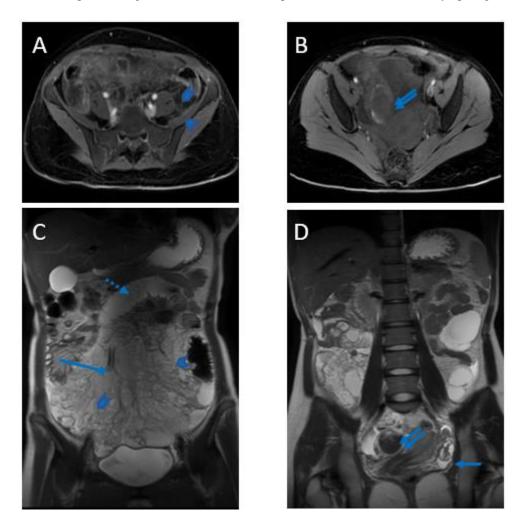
Magnetic resonance imaging (MRI) images. (A) Axial T1-weighted image (T1WI) post contrast venous phase showing multiple enhancing septations without solid mass (arrow heads). (B) Axial T1WI without intravenous (IV) contrast showing hyperintense periphery of hemorrhagic component (double arrow). (C) Coronal T2-weighted image (T2WI) showing mesenteric hyperintense cysts with variable signal intensity of different locules with numerous thin septations (arrow heads), normal flow void mesenteric vessels passing through the cystic structures without luminal narrowing (long solid arrow) and dilated small bowel (dotted arrow). (D) Coronal T2WI showing hypointense hemorrhagic cyst (double arrow) and normal left ovary (short solid arrow).
